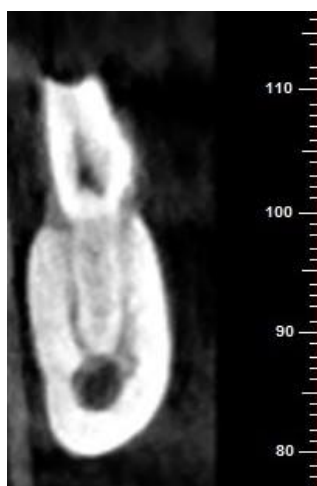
Cross sectional CBCT views for measurement of the distance from the tooth apex to the mandibular canal in a sample
